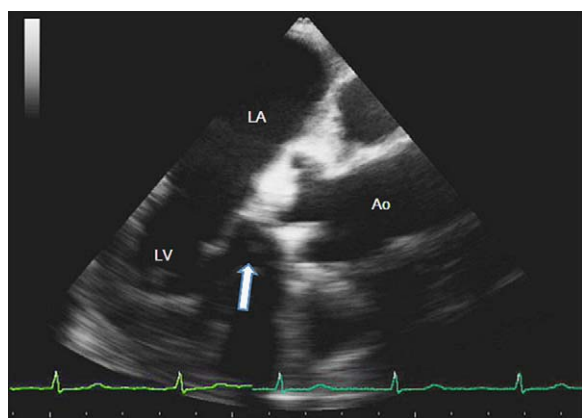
Transesophageal aortic valve long-axis view. Arrow points to a small vegetation attached to the ventricular side of the prosthetic aortic valve. Ao, aorta; LA, left atrium; LV, left ventricle.
